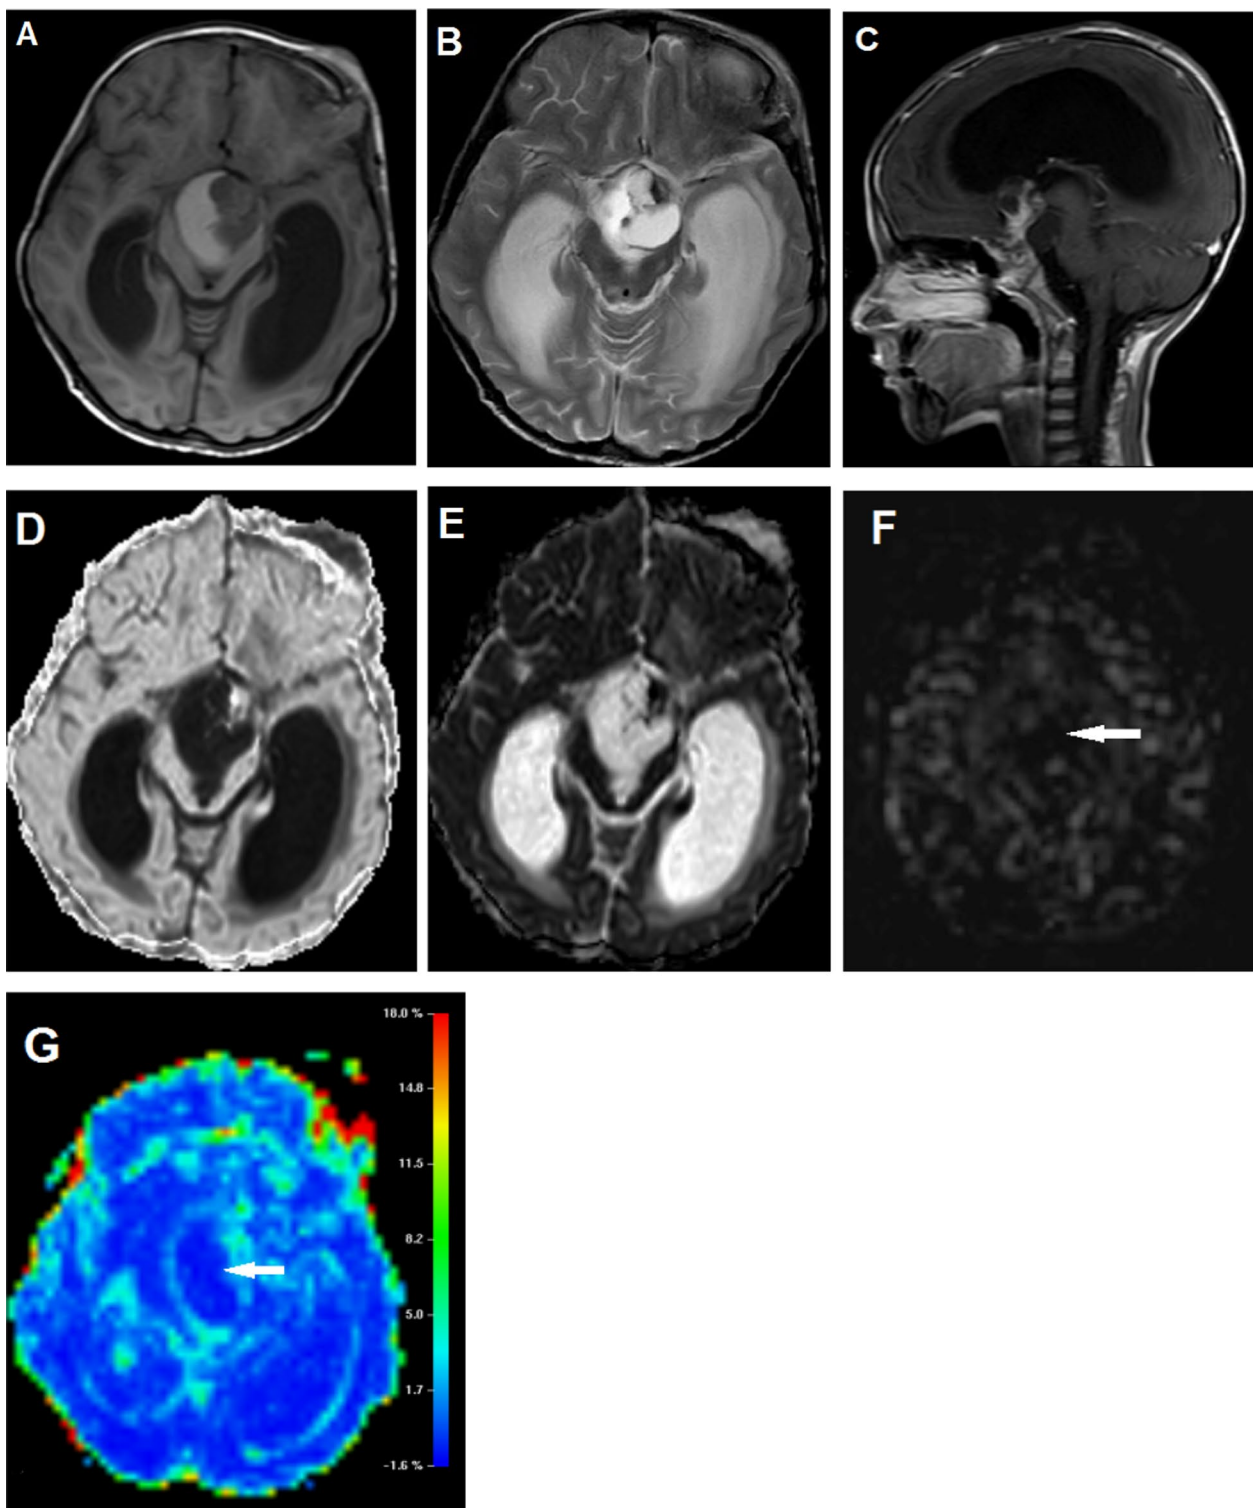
A 6-year-old boy patient with a WHO grade I adamantinomatous craniopharyngioma. Images show a well-defined partially cystic, partially solid supra-sellar mass complicated by supratentorial hydrocephalic changes. The cystic parts display high signal intensity on axial T1WI (A) and mixed high signal intensities on axial T2WI (B) denoting a high proteinaceous content. The solid parts show strong enhancement on post contrast sagittal T1WI (C). Free diffusion of the lesion is seen in the form of low SI on DWI (b1000 image) and high SI on axial ADC grayscale map (D, E). Hypo-perfusion of the lesion (white arrows) is demonstrated in the axial ASL grayscale and color CBF maps (F, G)
